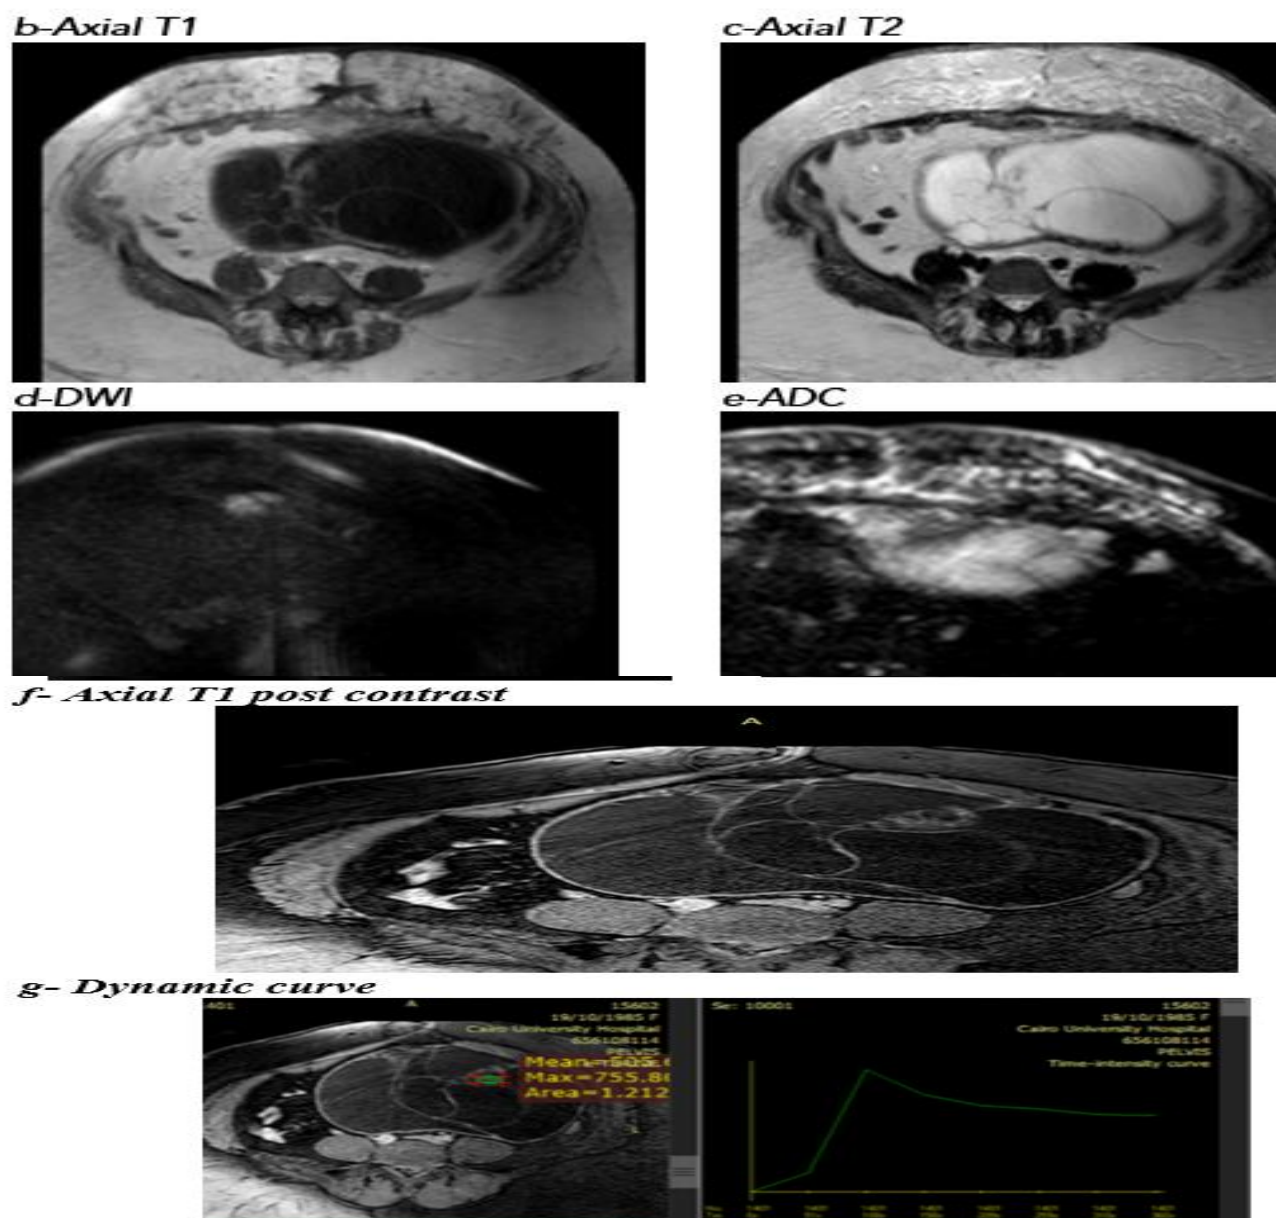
(a): Ultrasound images show a left multilocular solid cystic lesion with internal thick internal septations (reaching 6 mm). Color Doppler study revealed vascularity within the septations with color score 3 and RI=0.39. Conventional MRI: (b,c) axial T1 and T2 weighted images show a left pelviabdominal multilocular cystic adnexal lesion measuring 13 cm with multiple internal septations eliciting intermediate T1 and low T2 signal. (d&e) DWI show diffusion restriction of part of the honeycomb nodule. (f) Post-contrast axial and coronal T1 images show avid enhancement of the internal septations (g) DCE shows a type III curve: initial rapid rise followed by a rapid washout. Final pathological diagnosis (post left oophorectomy): Left mucinous borderline ovarian tumor.
